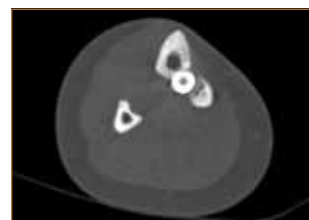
Six months after surgery, axial computed tomography shows wedge segmental fragment anterior displacement caused by failure of intramedullary rod to cannulate intramedullary canal of fragment properly.
